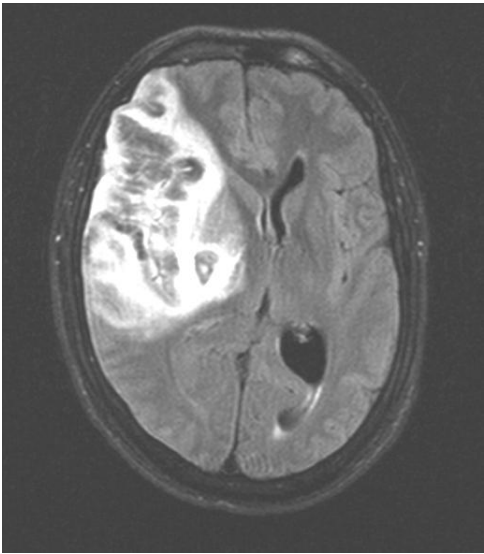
Magnetic resonance image of a large cerebral infarction with hemorrhagic transformation, which is visible as the white area.
